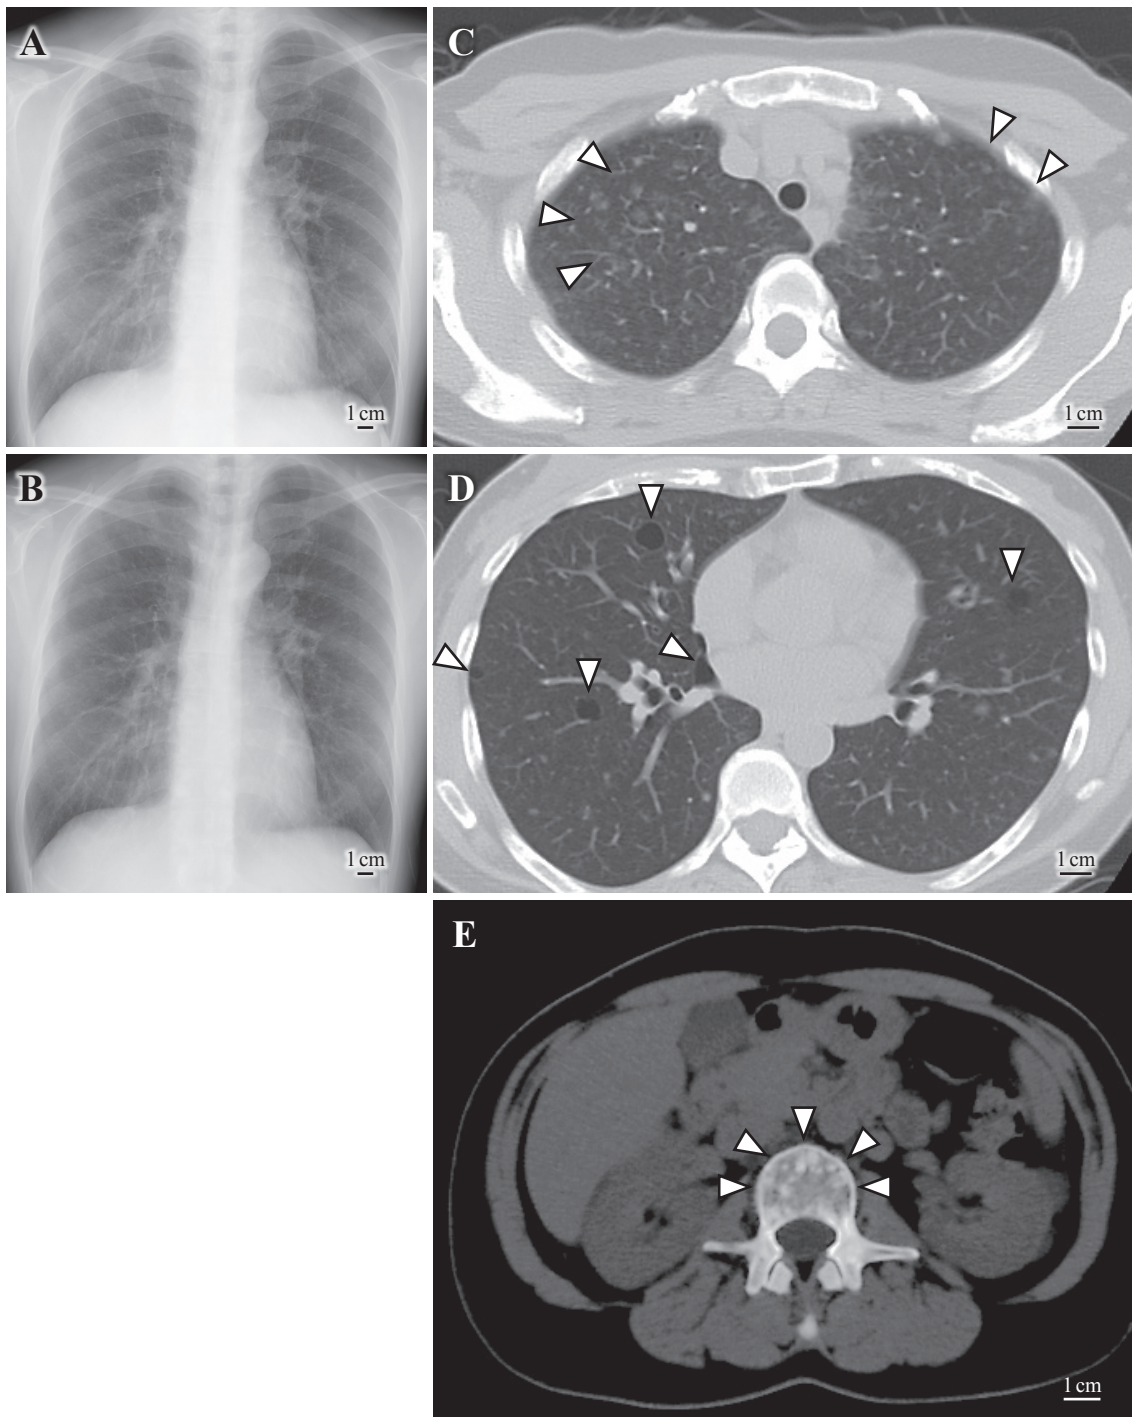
The radiological findings of Case 2. The chest radiographs on the first visit (A) and four years after the first visit (B) show no remarkable changes. A chest CT shows multiple small ground-glass attenuations (arrowheads) predominantly in the bilateral upper lobes (C) and plural cysts (arrowheads) in the bilateral lungs (D). The bone window image of a chest CT reveals bone sclerosis lesions at L1 (arrowheads) (E) with bone cysts.
